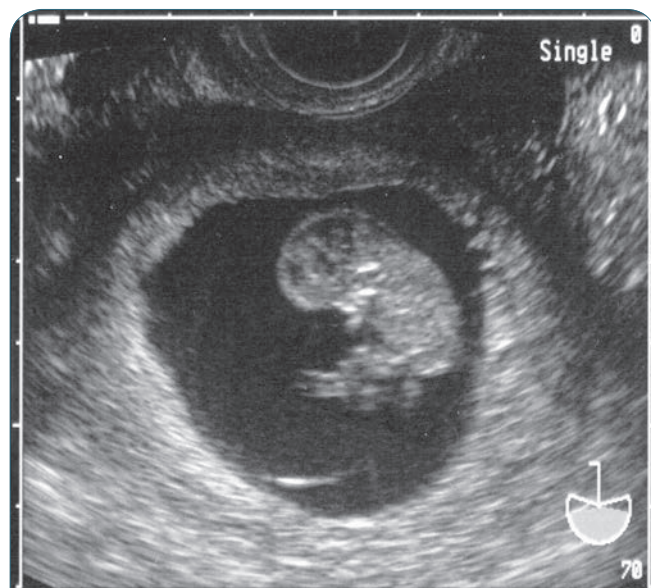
Sonogram taken in the second trimester of pregnancy.
